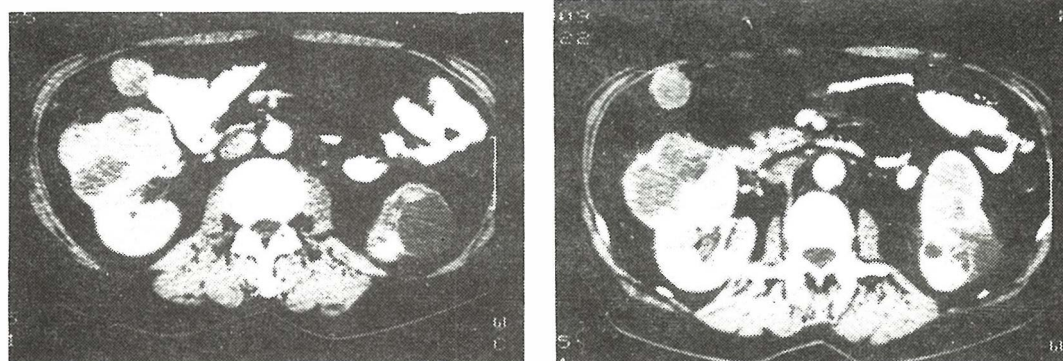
CT slices after contrast application. Notice irregular tumor opacity.
